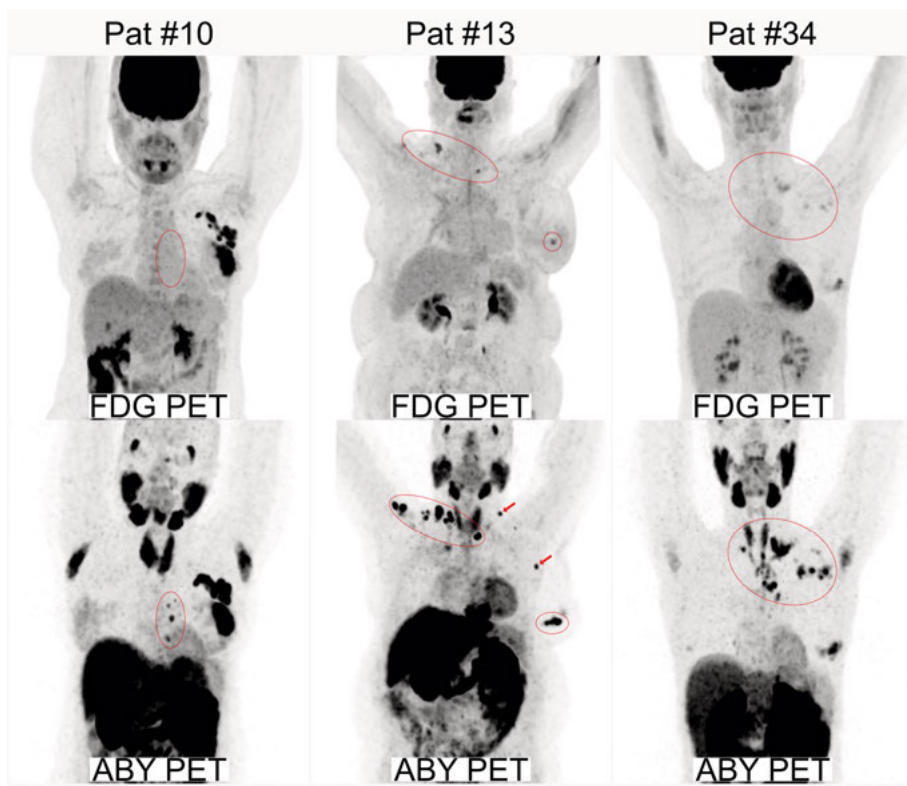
Patients with low metabolic activity in tumor lesions not detectable by ^{18}F -FDG PET, the same lesions were detectable using ^{68}Ga ABY-025 PET (patient #10 had ductal carcinoma, while patient #13 and patient #34 had lobular carcinoma).
